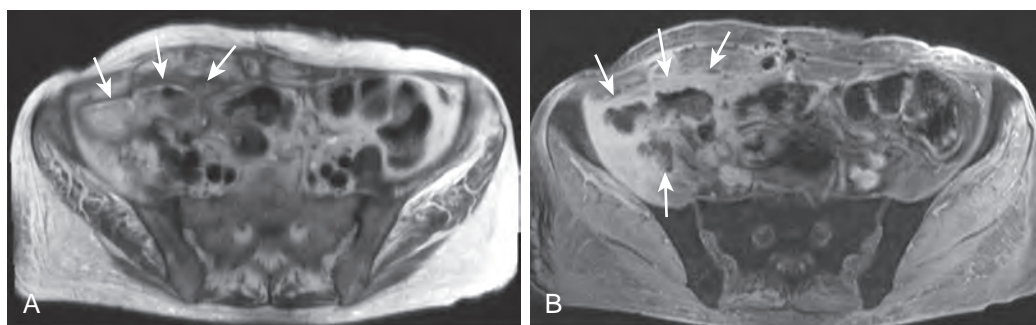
MRI in diagnosis of intraperitoneal abscess. A. Axial T2-weighted image demonstrates a right lower quadrant abscess (arrows) in a 24-year-old man with Crohn's disease. The abscess demonstrates heterogeneous T2 hyperintensity. B. Post-gadolinium-enhanced fat-suppressed T1-weighted image shows intense peripheral enhancement of the abscess wall and the surrounding structures, indicating inflammatory involvement (arrows).
